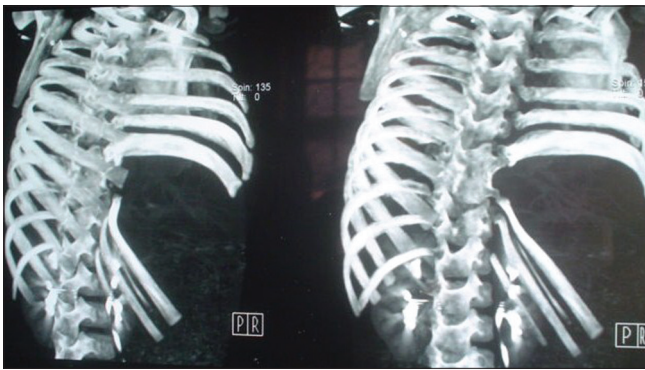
3D computed tomogram showing rib defect in patient B
